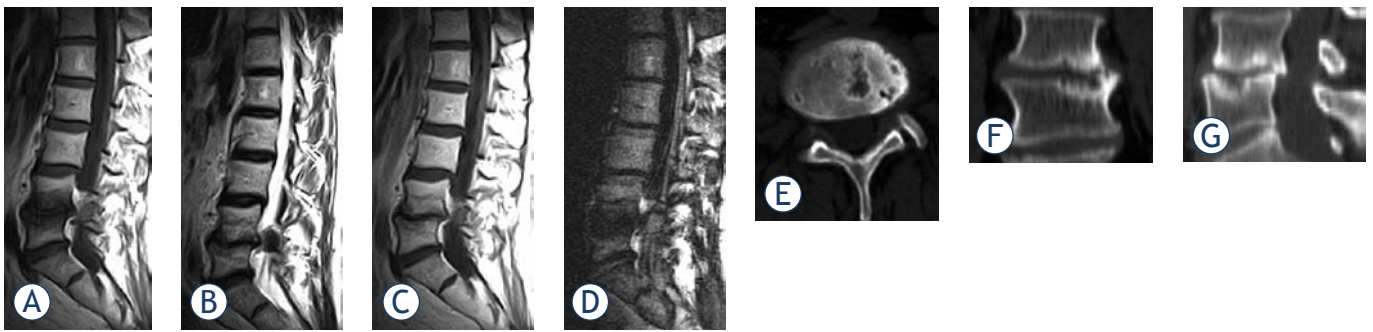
Sagittal MR images from 48 years old male patient with low back pain. A) Sagittal T1-weighted and B) Sagittal T2-weighted MR images showing low and high signal respectively at both end-plates of L4-5. C) On post-contrast T1-weighted images same level demonstrating heterogenic contrast enhancement. D) On DWI end-plates demonstrating low signal intensity changes consistent with Modic type 1 change at L4-5. E) Axial CT slices obtained from the L4-5 disk level and F) Coronal and G) Sagittal reconstructed CT image showing sclerosis on both end-plates of L4-5.
